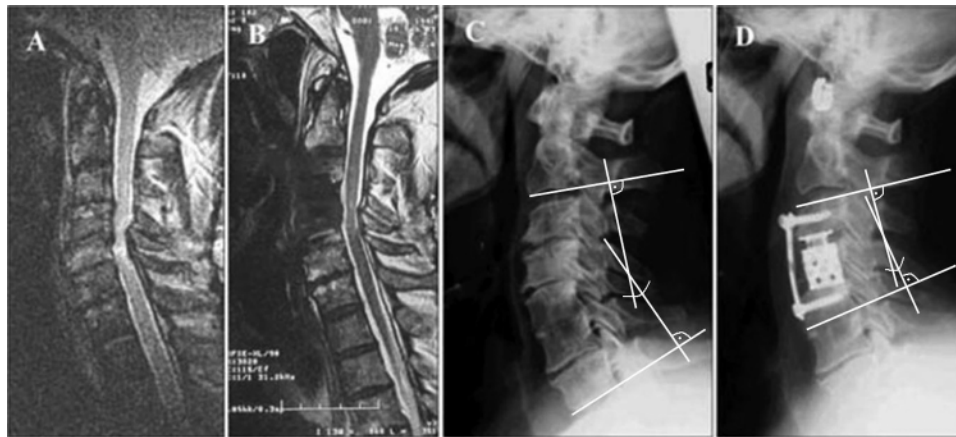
Sagittal preoperative (A and C) and postoperative (B and D) images of a patient with progressive myelopathy resulting from cervical spinal canal stenosis (A). A corpectomy and reconstruction of the anterior column was performed using an anterior distraction device with a plate (D). Postoperative MR imaging demonstrated sufficient decompression (B). A postoperative radiograph shows good cervical balance (D). The methods of measurement for the cervical and segmental lordosis are shown in panels C and D, respectively.
